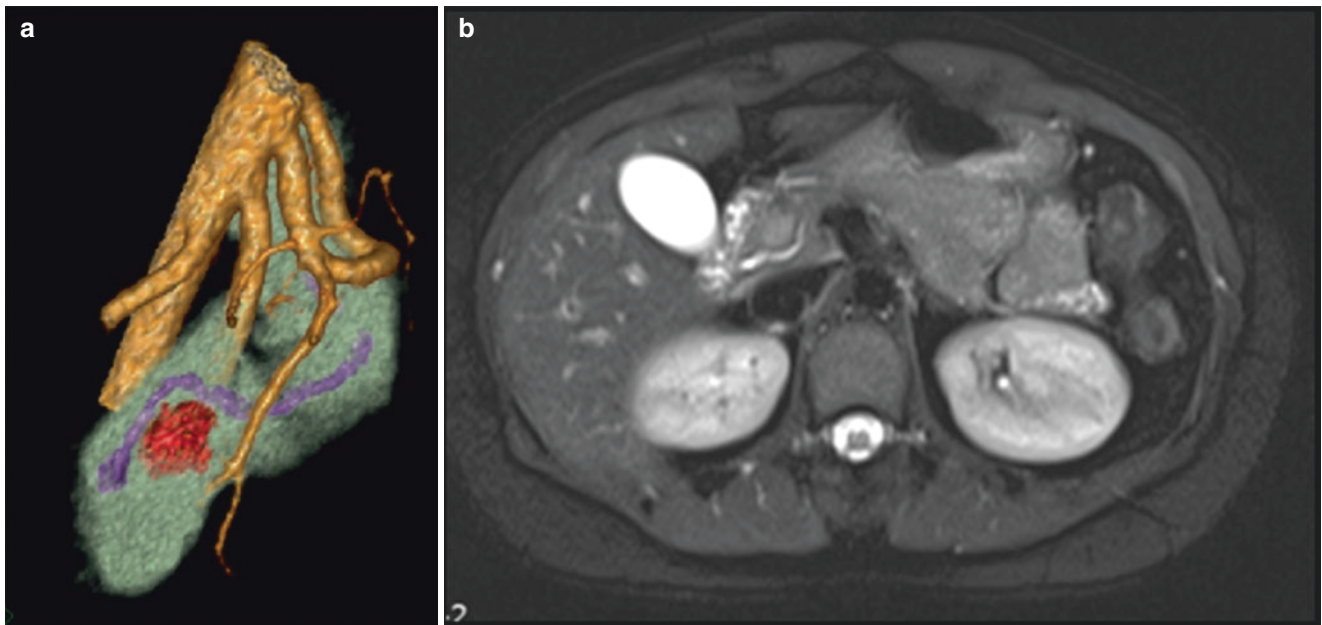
(a) Abdominal 3D CT measured a 3 mm distance of pancreatic head mass (red) to MPD (purple) as well as demonstrated aberrant vascular anatomy of CA (yellow) giving rise to right hepatic artery, left
